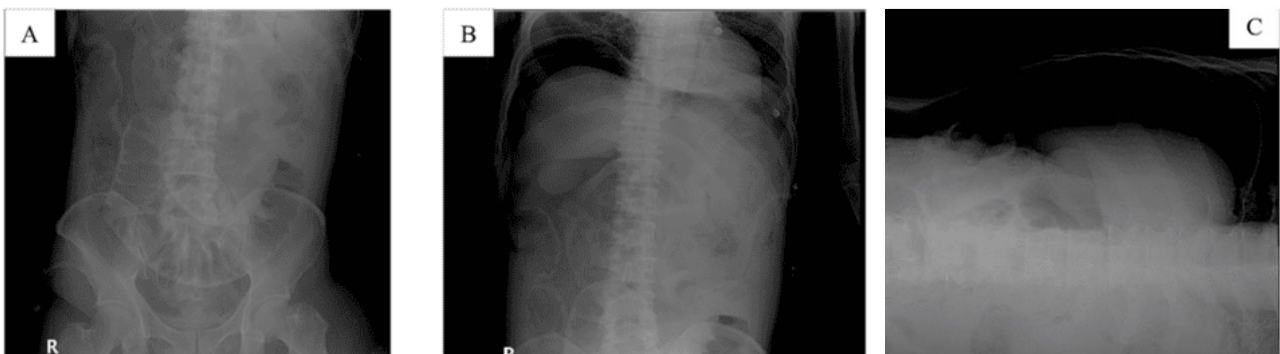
Three-Position Abdominal X-rays (A) supine, (B)erect, and (C) left lateral decubitus position. An infra diaphragmatic and superior hepatic free air picture forming a lateral decubitus sign. Multiple short air fluid levels of more than 5 are seen forming a pathological step ladder picture, lead to imaging of pneumoperitoneum and small bowel obstruction.
